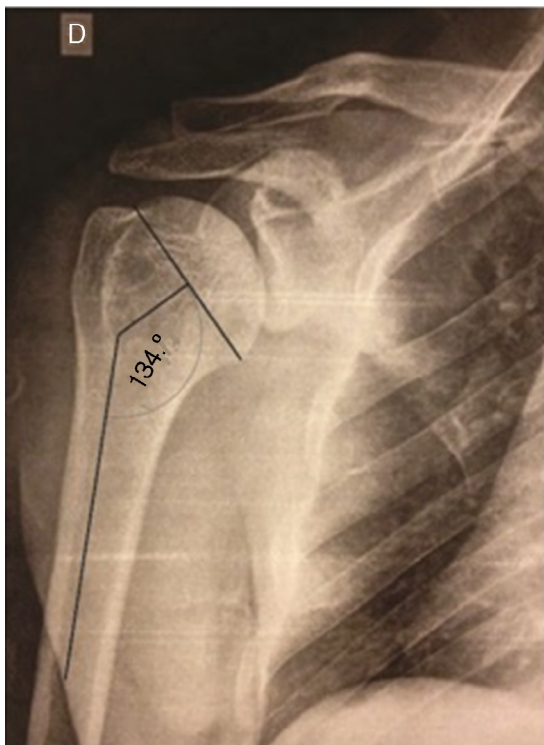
Radiograph showing measurement of the cervicodiaphyseal angle of the proximal humerus, i.e. the angle between the anatomical neck and the axis of the humeral diaphysis.
